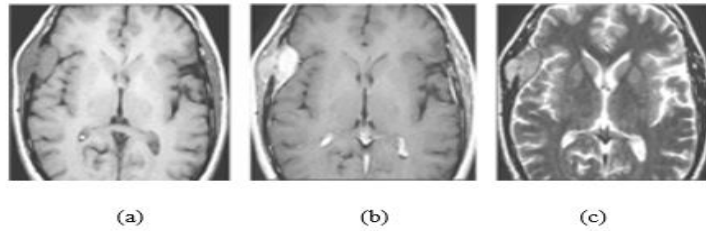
A completely developed tumour devoid of edema. a) T1-weighted image's axial slice. b) The identical T1-weighted image slice that has been increased with contrast. c) A T2-weighted picture
